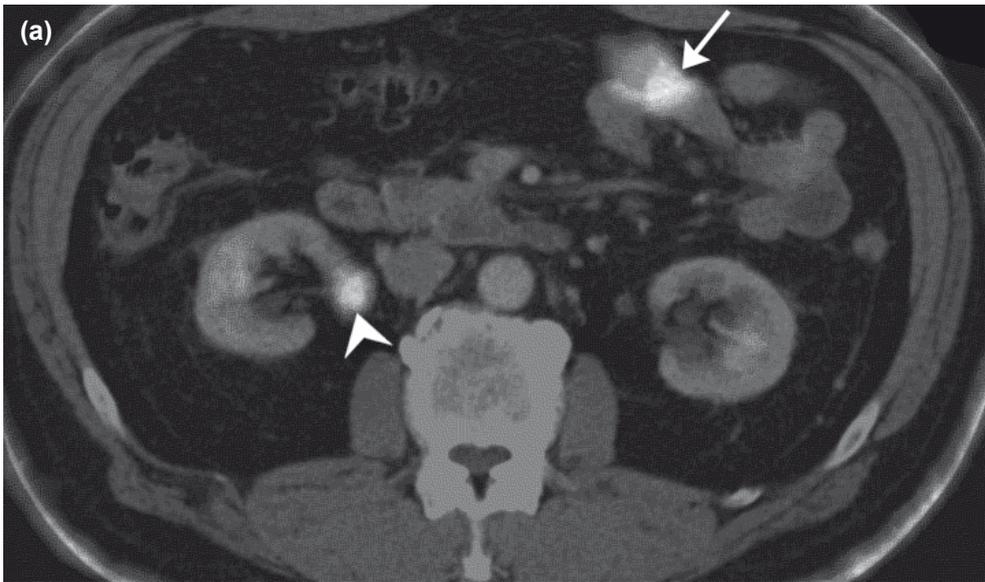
Melanoma metastasis. PET/CT (a) shows focal increased FDG-uptake in jejunal loop. FDG excretion in right renal pelvis (arrowhead). (b) Axial True FISP with fat saturation shows focal mild asymmetric thickening of jejunum (arrow).
